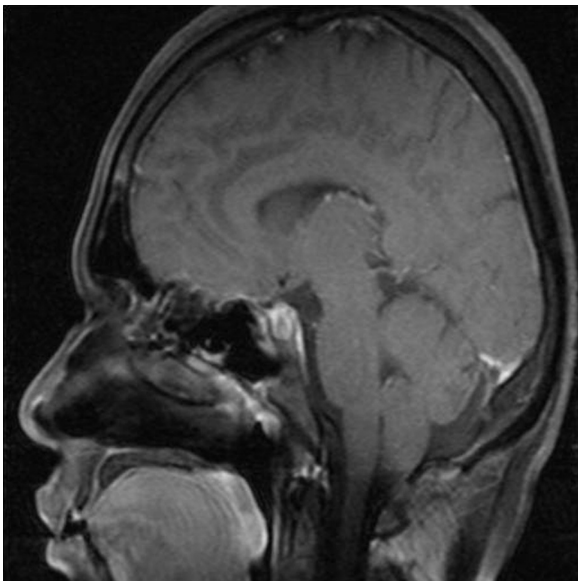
Contrast enhanced Magnetic resonance imaging (MRI) scan (Sagittal view) of the brain showing enlarged pituitary gland with homogenous enhancement.
